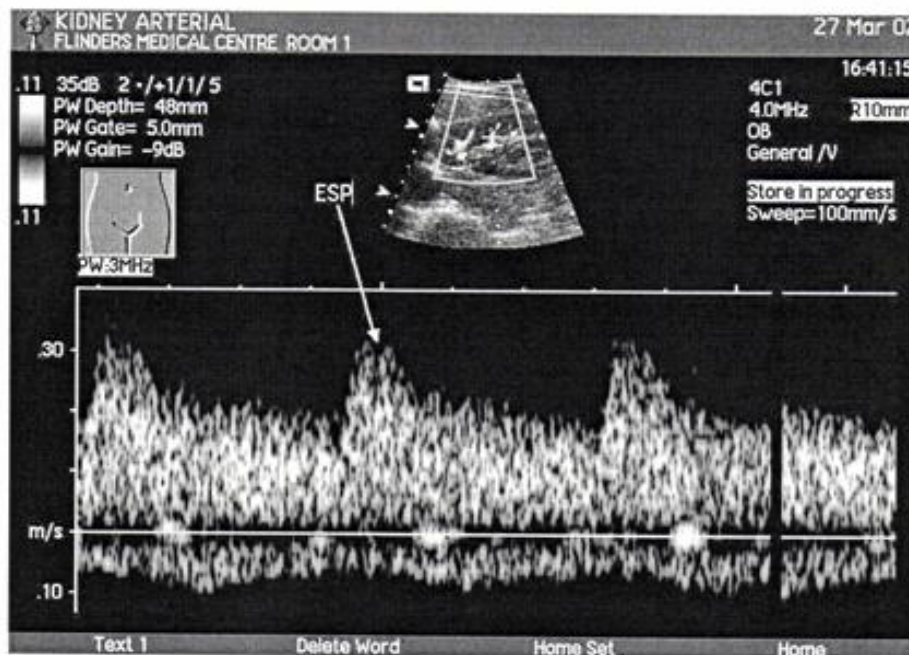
Intra-arterial PW Doppler tracing demonstrating the early systolic peak (ESP)
